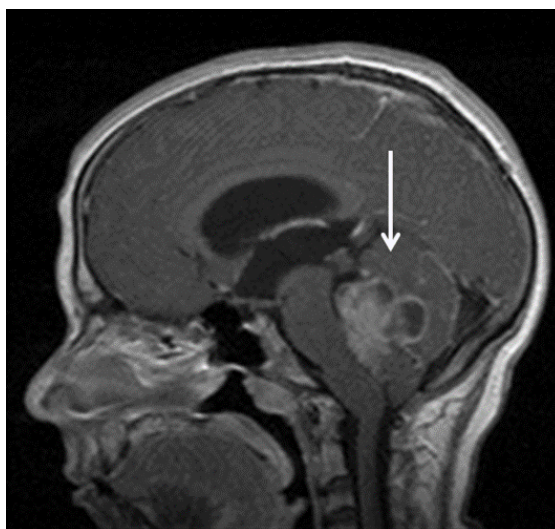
MRI of a medulloblastoma. Sagittal view of a cranial MRI image of a patient with medulloblastoma, indicated by the arrow. Image provided by Prof. Simon Bailey (PBTG, Newcastle).
